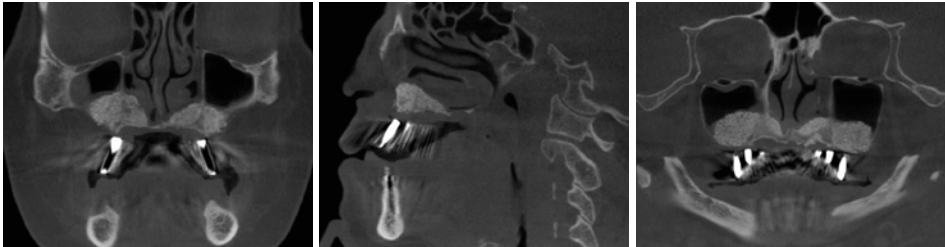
CT coronal view Fig. 4-2 CT cephalic view Fig. 4-3 CT panoramic view after bone graft
